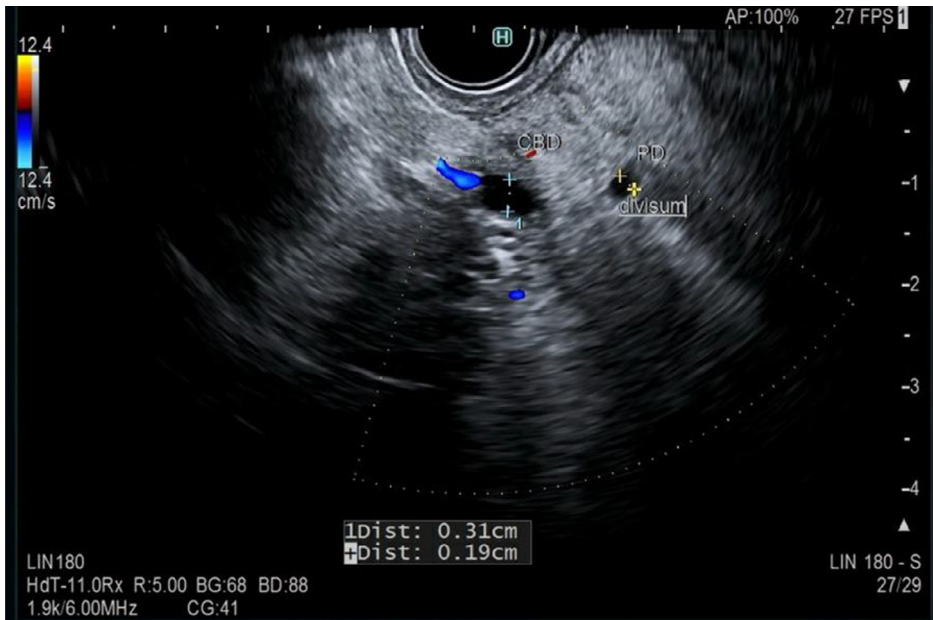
Endoscopic ultrasound showing pancreatic divisum
